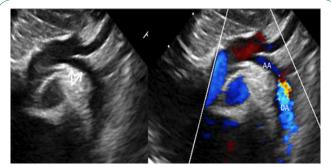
Suprasternal view in two-dimensional echocardiography (left) with color-flow Doppler (right) depicting hypoplastic aortic arch (thick arrow). MV: Mitral Valve; LVOT: Left Ventricular Outflow Tract; VSD: Ventricular Septal Defect; CS: Coronary Sinus; AO: Ascending Aorta; IVS: Interventricular Septum; RV: Right Ventricle, LA; left atrium; LV: Left Ventricle; AA: Aortic Arch; DO: Ascending Aorta.
